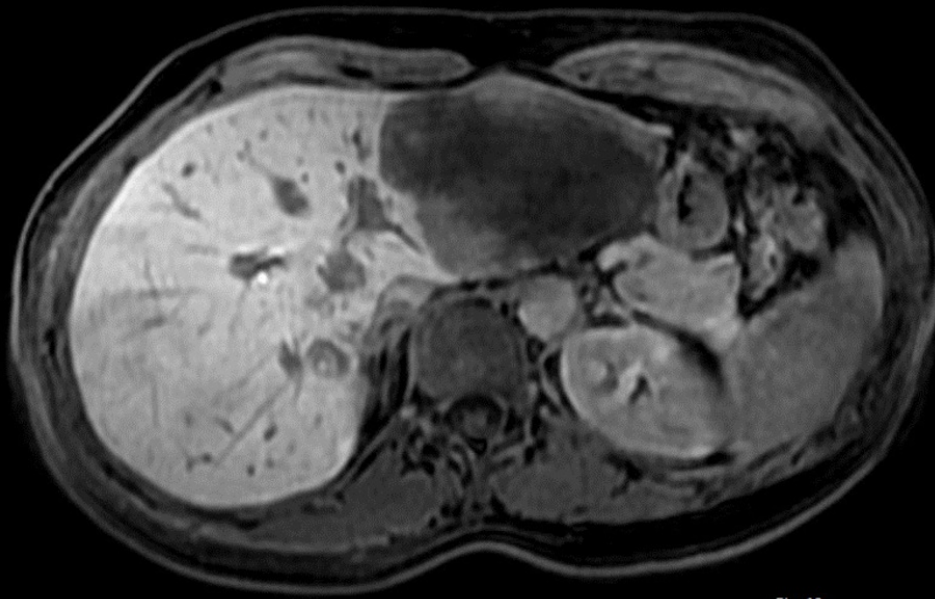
MRI performed two years after diagnosis and OC withdrawal: axial T1 LAVA after gadoxetic acid administration during arterial phase
